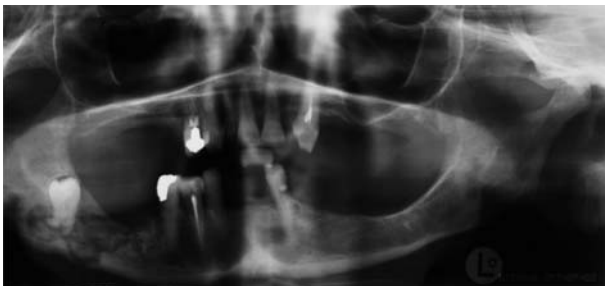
Radiographic view of the osteonecrosis of the right mandible in a female patient (B.L.) with bone metastasis under treatment with pamidronate and zoledronate.
